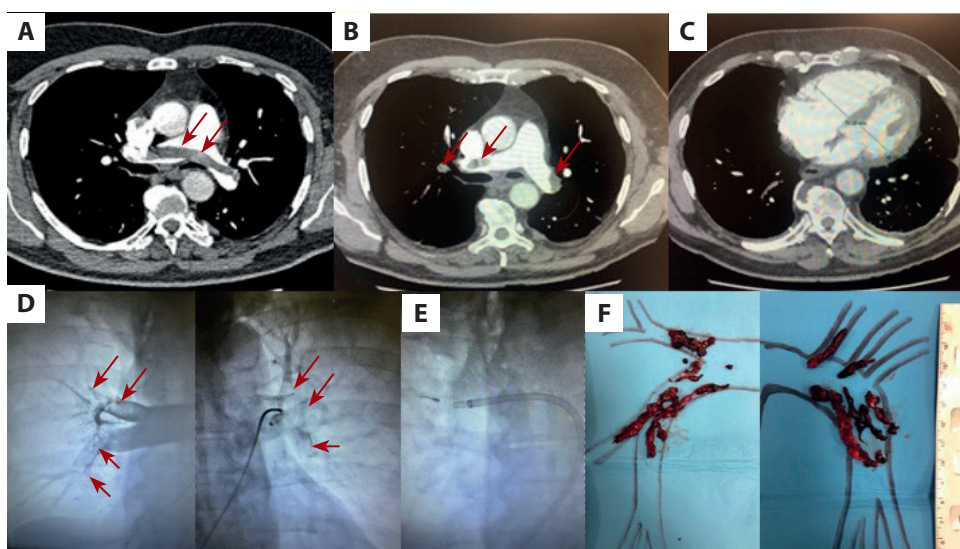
A. Computed tomography pulmonary angiography (CTPA) demonstrating a saddle embolus (SE) (red arrows) straddling the pulmonary trunk bifurcation extending bilaterally into the main and lobar arteries but with preserved contrast flow in the segmental branches. B. CTPA demonstrated fragmentation of the SE with occlusion of the lobar and segmental arteries (red arrows). C. Catheter-directed mechanical thrombectomy — a right ventricle to left ventricle (RV/LV) ratio increased to 1.5 D. Pulmonary angiography revealing bilateral lobar arteries occlusion by central clots (red arrows). E. CAT12 Lightning 12 system with separator wire in the right pulmonary artery. F. An image of the clots removed from the right and left pulmonary arteries
